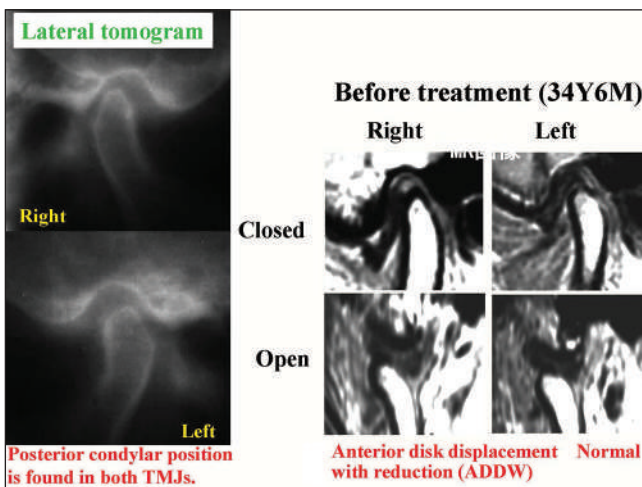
Posterior position of both condyles on lateral tomograms (left) and anterior displacement of right articular disk with reduction on magnetic resonance images (right)
